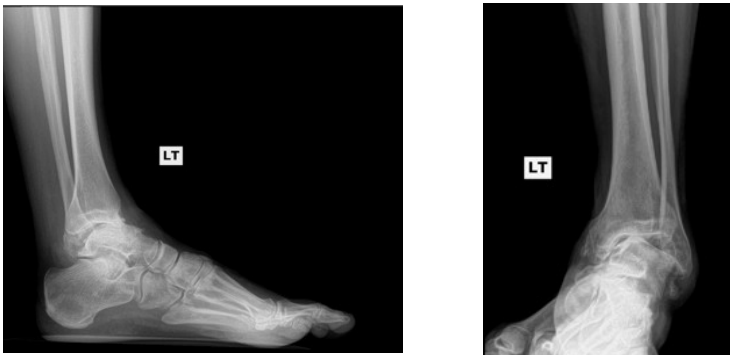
Pre-operative x-rays showed ankle arthritis and significant varus deformity.
